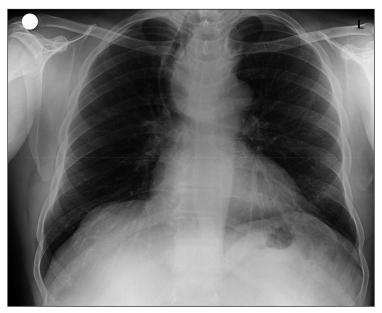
Chest X-ray showed significant right tracheal deviation.
